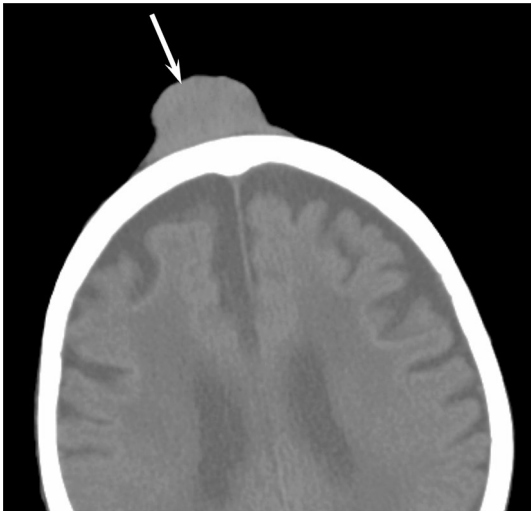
A 98-year-old woman with merkel cell carcinoma. Unenhanced CT image shows a homogeneous soft-tissue lesion (arrow)
